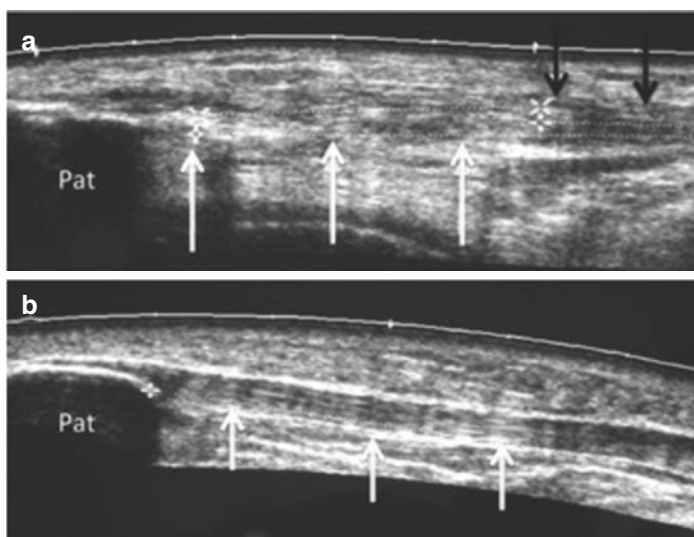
Ultrasound of a normal patellar tendon and a chronic patellar rupture. (a) The proximal patella (Pat) is visualized on the left side of the image. The hypoechoic region (white arrows) indicate development of scar tissue. The remaining distal tendon is visible (black arrows). (b) Ultrasound image of a normal patellar tendon. (Source: Magnussen R.A., Demey G., Archbold P., Neyret P. (2014) Patellar Tendon Rupture. In: Bentley G. (eds) European Surgical Orthopaedics and Traumatology. Springer, Berlin, Heidelberg. https://doi-org.eresources.mssm.edu/10.1007/978-3-642-34746-7_137)
